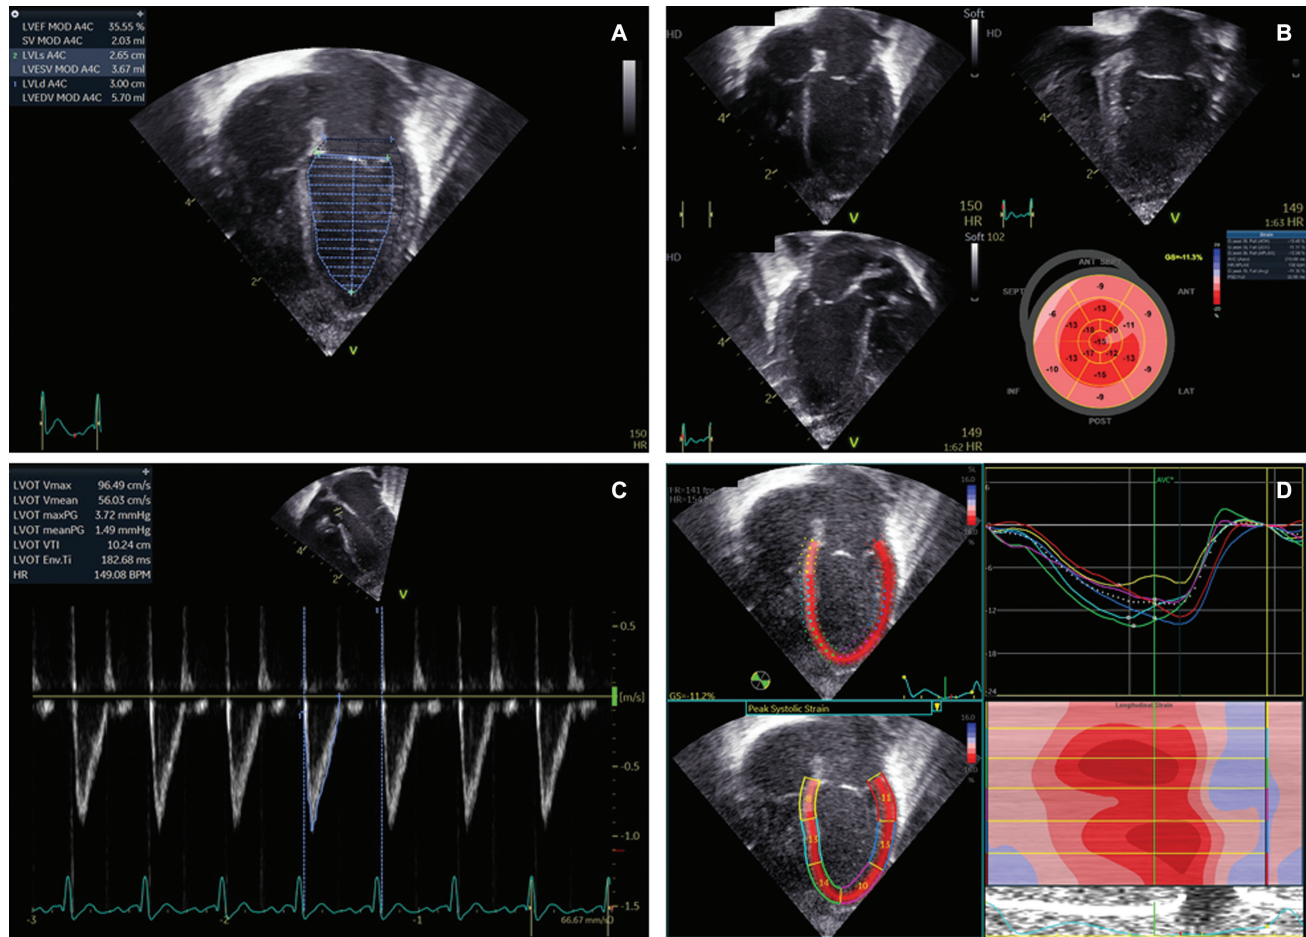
Echocardiography imaging on postnatal day 7 demonstrating decreased ejection fraction (A) with a preserved left ventricular output (C). Echocardiographic strain imaging (myocardial deformation analysis) demonstrating decreased systolic function (Global longitudinal strain [GLS] = -11.3%) (B, D).
